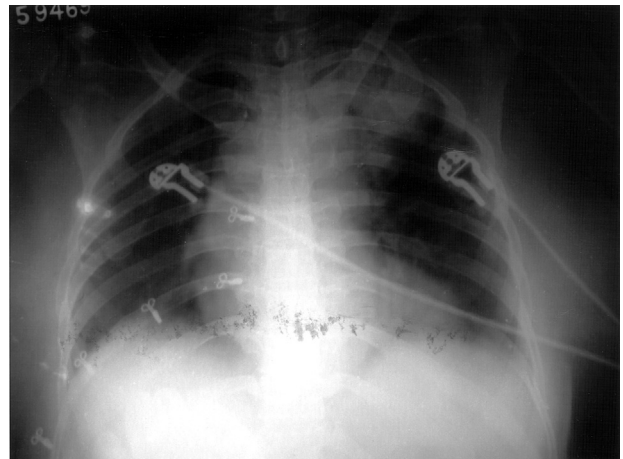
Chest radiograph (postero-anterior view) showing left upper lobe consolidation.
